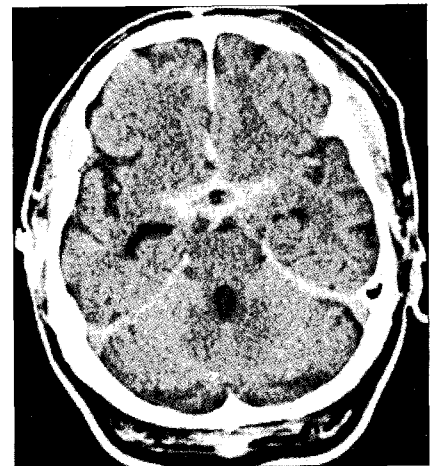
Brain computed tomography scan, demonstrating diffuse subarachnoid hemorrhage around basal cisterns.
